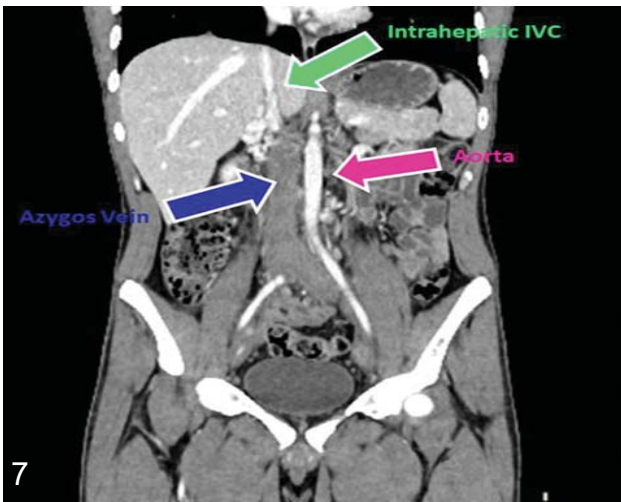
CT scan with contrast coronal images showing infrahepatic interruption with azygos continuation.
